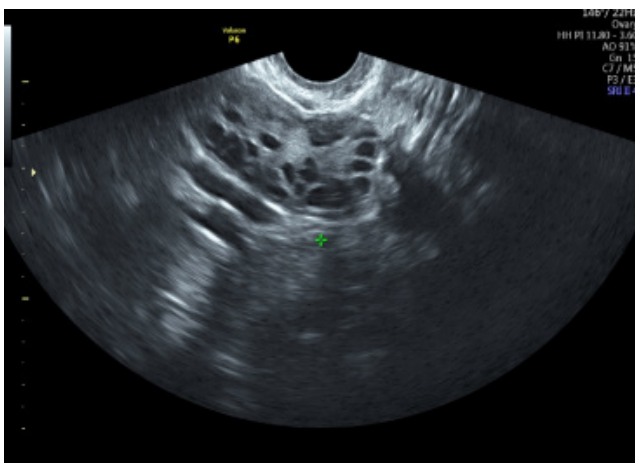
Ultrasonographic image showing PCOM
